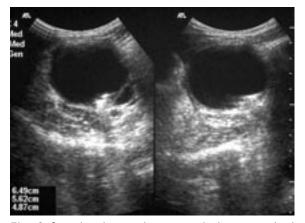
Sagittal and coronal transvaginal ultrasonographical images of the right adnexa.
